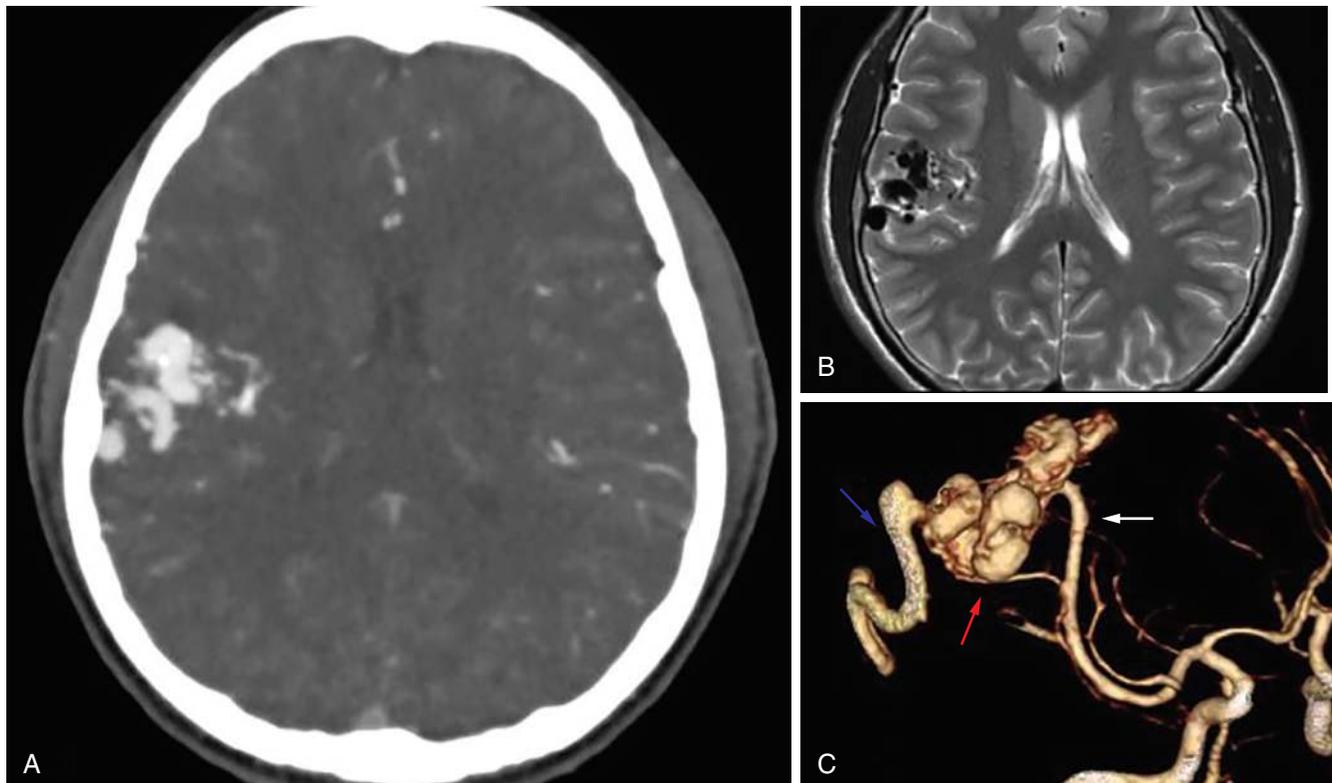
Arteriovenous malformation. A, CT with contrast shows hyperdense tubular structures in the right frontal lobe representing the enlarged enhancing vessels of an arteriovenous malformation. B, T2-weighted MRI shows the vessels to be hypointense and devoid of signal. This lack of MRI signal is the result of rapid flow of blood. C, CTA of the head viewed as a volume-rendered reconstruction demonstrates the arterial feeders (*white arrow*), nidus (*red arrow*), and draining vein (*blue arrow*) of the arteriovenous malformation. Identification of these components is important for treatment planning and surgical approach.
